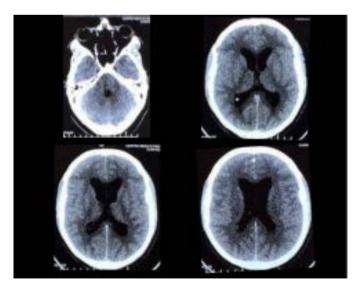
Simple axial computed tomography of the skull, in which a dilated fourth ventricle is observed, as well as a rounded third ventricle, lateral ventricles with predominance of occipital horns, with evidence of transependymal leak, as well as loss of the arachnoid mantle towards the convexity.
